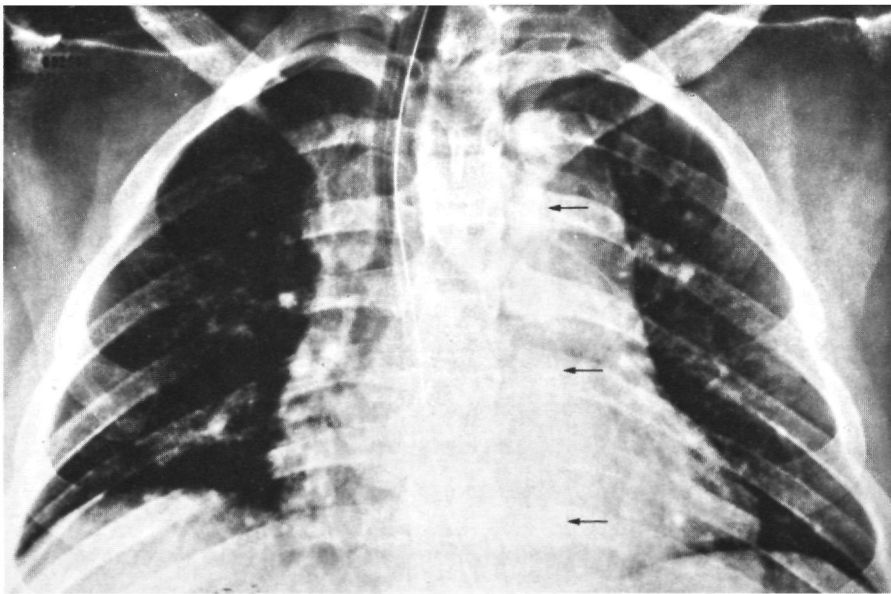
3 Typical presentation of a patient with TAR (male, 23 years, car passenger, uneventful recovery after operation). Chest X-ray: trachea and nasogastric tube displaced to the right. Widening of the mediastinal shadow (12 cm). Caudal displacement of the left main bronchus. Widened left paraspinal line (arrows).
